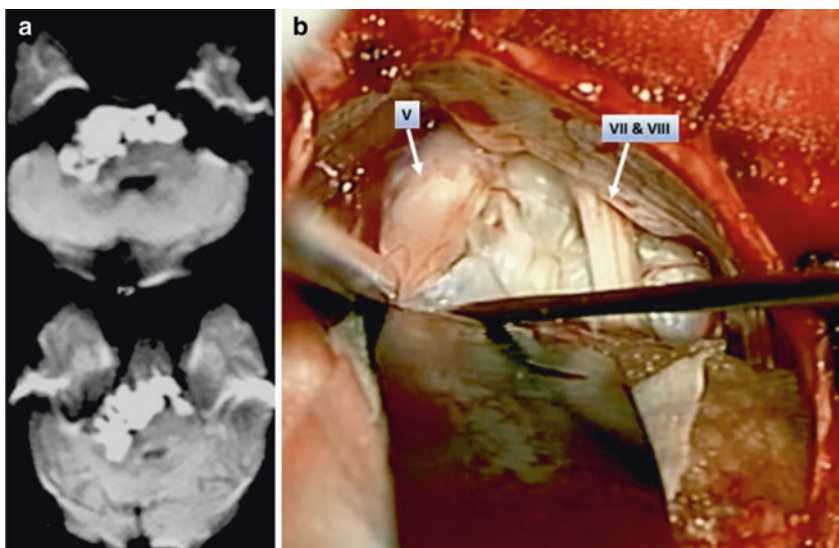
Case 4. (a) Presigmoid approach to the CPA and middle fossa showing the meningioma in the cerebellopontine angle (TU). (b) After radical removal of the tumor the cranial nerves V, VII, and VIII are identified. (c) Postoperative MRI (T1-wGd) demonstrating radical removal of the tumor
